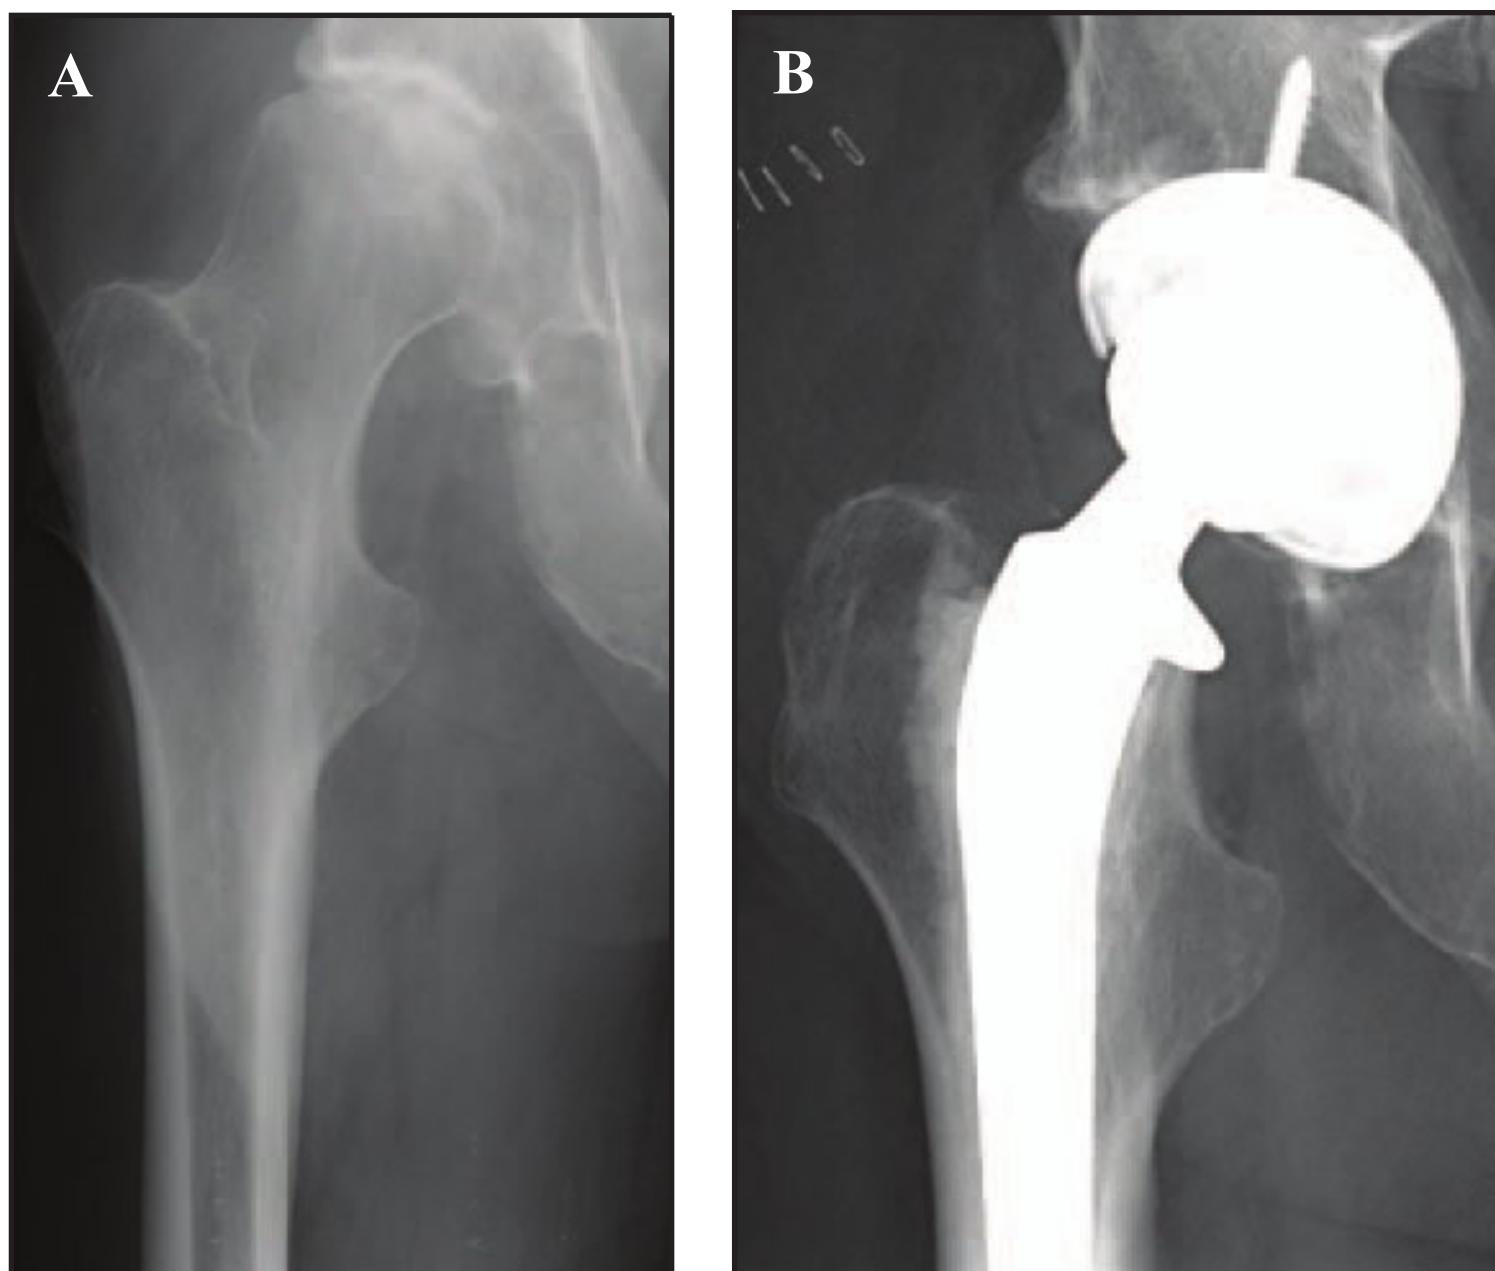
(A) AP radiograph of a patient with significant coxa valga. A high ( $>20$  mm) neck cut and short neck component were utilized in order to maintain offset and length. (B) A high ( $>20$  mm) neck cut and short neck component were utilized in order to maintain anatomic offset and length.
